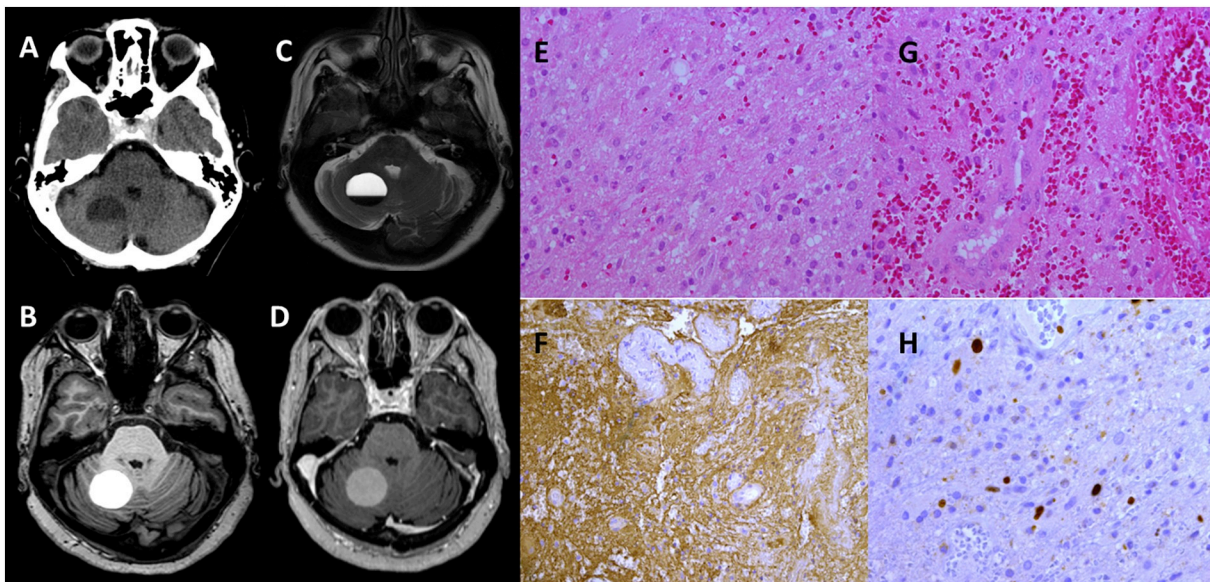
A - Non-contrast axial CT Scan revealing a mixed density lesion with a probable cystic component and a fluid level; B - non-contrast T1-weighted; C - T2-weighted; D - T1-weighted post-GAD; E - Hypercellular glial tissue composed of fibrillary and sporadic pilocytic astrocytes with hyperchromatic and pleomorphic nuclei, mitotic features and microvascular proliferation (HE $\times 40$); F - GFAP immunoreactivity, ATRX (no mutation) and P53 immunoreactivity but IDH1 immunonegativity; G - Endothelial proliferation of the tumour vascularization (HE $\times 40$); H - High proliferative index of 20% (Ki67 $\times 40$). Further sequencing showed no IDH1, IDH2, BRAF, H3F3A, hTERT mutations and unmethylated MGMT.
